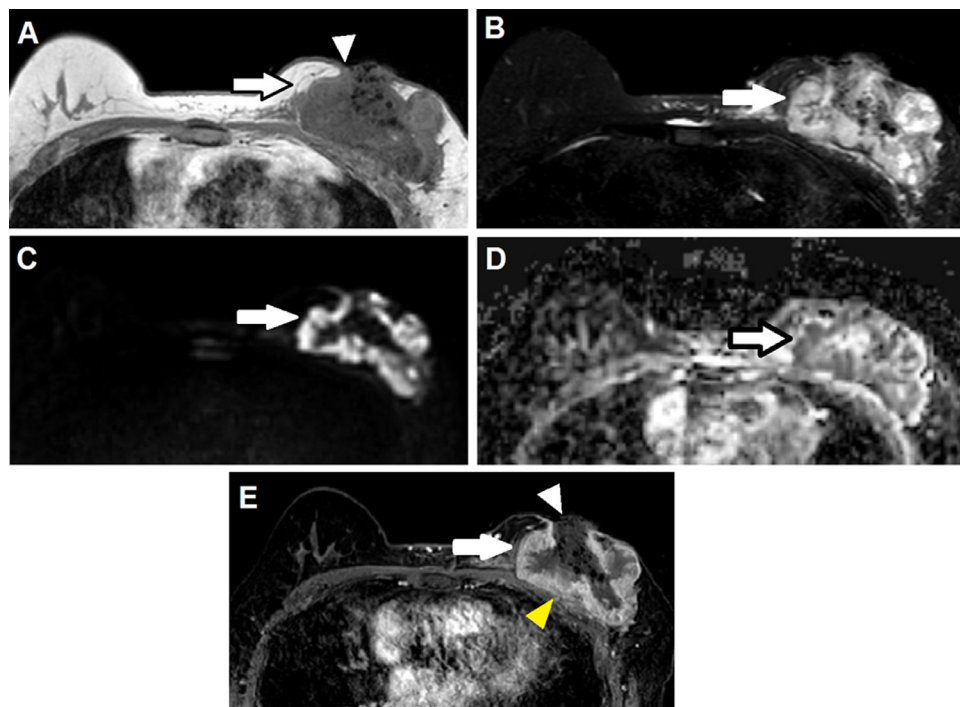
The mass was hypointense on T1-weighted images (A, arrow) and hyperintense on T2-weighted images (B, arrow), with restricted diffusion (C and D, arrows), and was markedly enhanced (D, arrow). The mass invaded the skin (A and E, arrowheads) and chest wall (E, yellow arrow).
